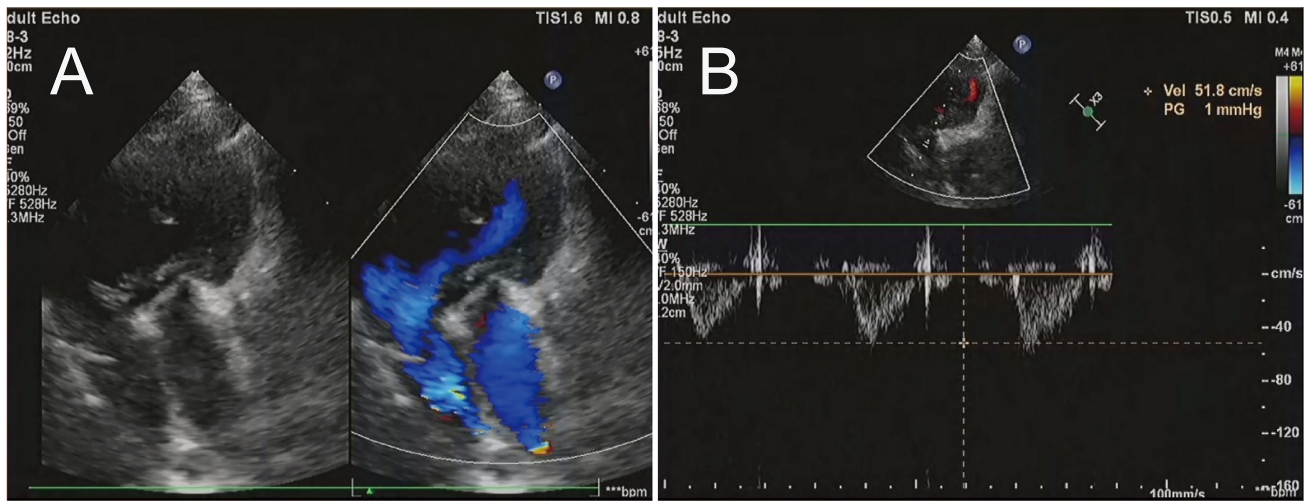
The postoperative echocardiographic findings at a 17-month follow-up. (A) Unobstructed right ventricular outflow and pulmonary artery, mild aortic regurgitation with 0.4 cm^2 , and no residual shunt were shown. (B) The flow velocity through the pulmonary valve was 0.5 m/s , indicating no stenosis and satisfactory conduit performance.
